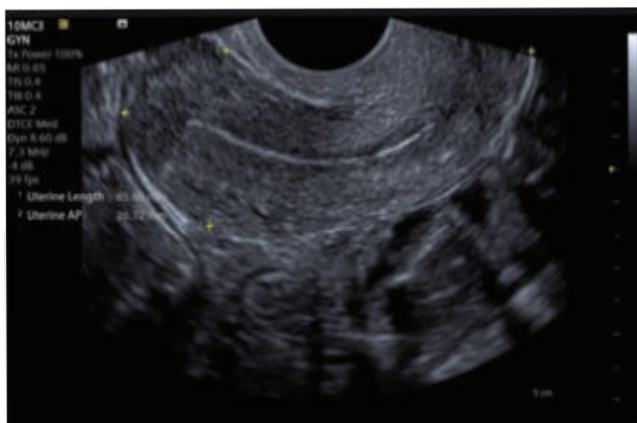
Normal findings of uterus in ultrasonography.
